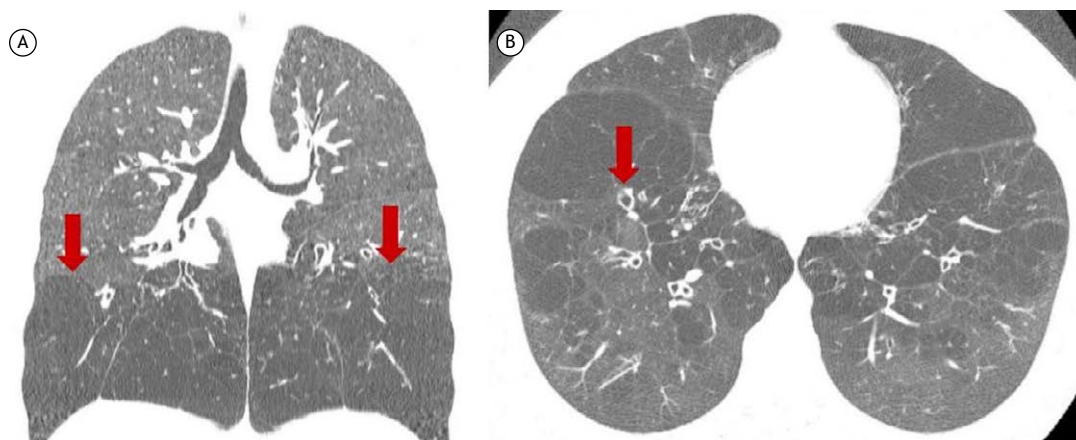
Axial CT scans with lung window settings of a male patient with alpha-1 antitrypsin deficiency. In A, a coronal scan showing areas of symmetric decrease in attenuation of the lung parenchyma and in vessel calibers at the lung bases (arrows). In B, a CT scan showing bronchiectasis (arrows).
